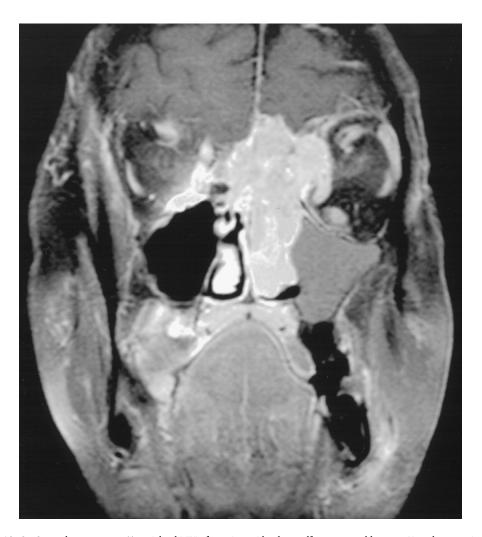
Coronal post-contrast T₁-weighted MRI of a patient with a large olfactory neuroblastoma. Note the extension of this tumor intracranially and into the left orbit.
